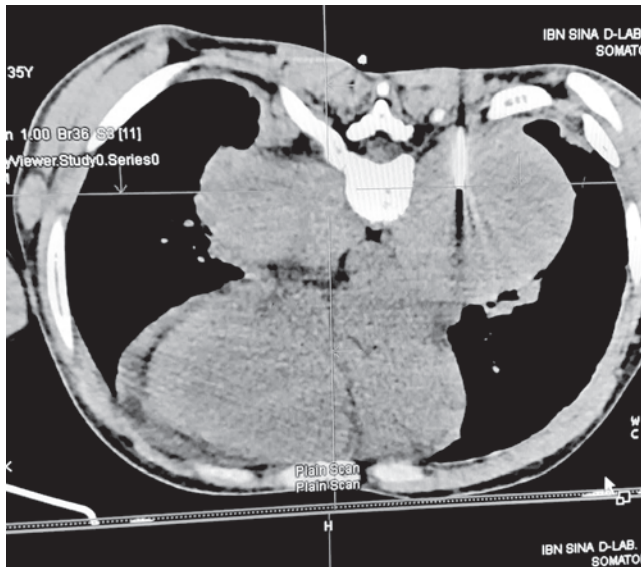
Contrast-enhanced axial CT of the chest
